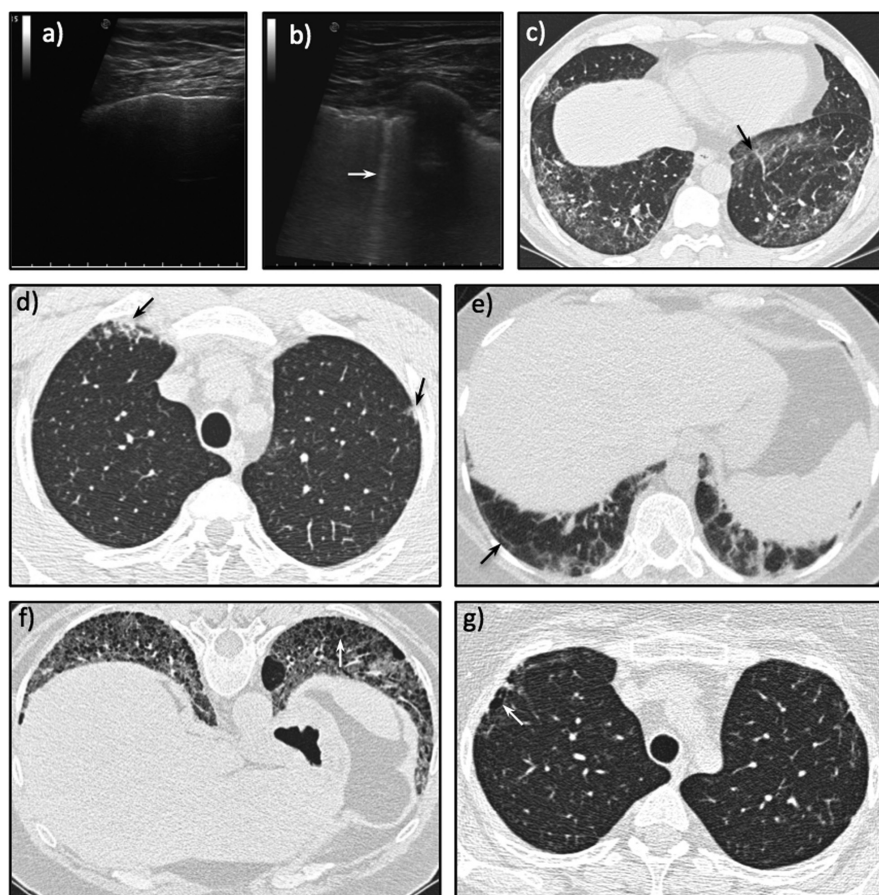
Images showing: a) Normal sonographic point. b) Sonographic point with one B-line (white arrow). c) Ground glass appearance (black arrow). d) Irregular pleural margins (black arrows). e) Septal/subpleural lines (black arrow). f) Honeycombing (white arrow). g) Subpleural cysts (white arrow).
